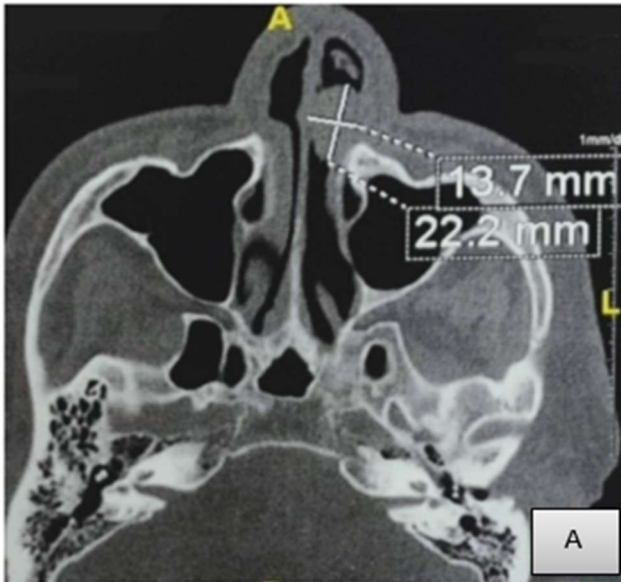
Axial section (A) and sagittal section (B) of a computed tomography scan showing a polypoid formation originating at the nasal septum filling almost the entire left nasal cavity without osteolysis.
